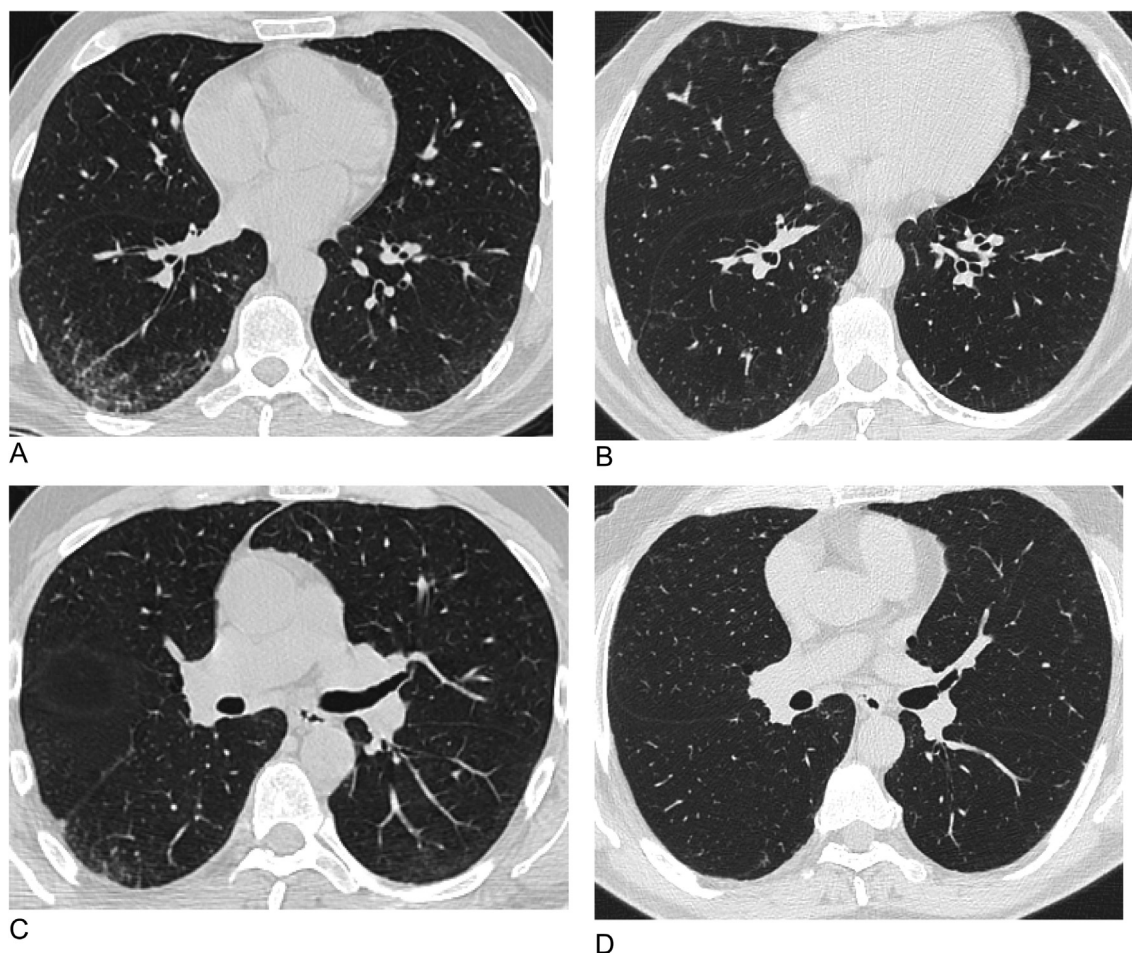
Comparison between HRCT images before (A and C) and after (B and D) 1 month of high dose steroid therapy.
